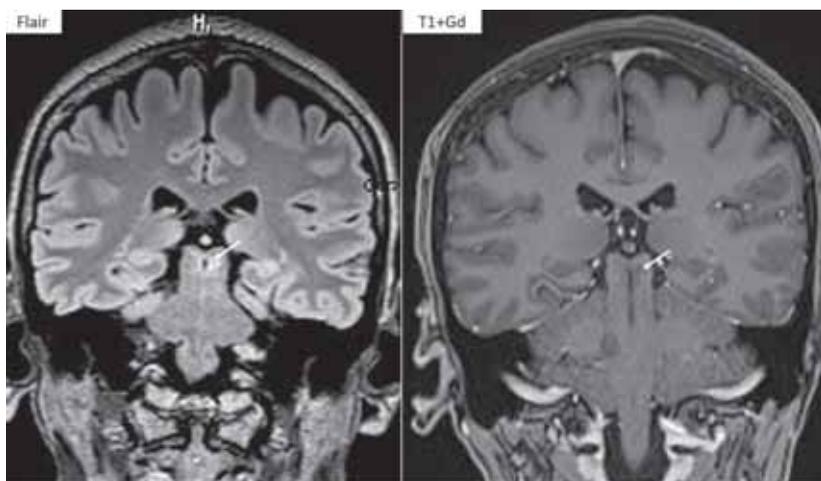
Coronal images revealing small hyperintense lesion on FLAIR, non-enhancing on T1+Gd, located in the left periaqueductal gray.
